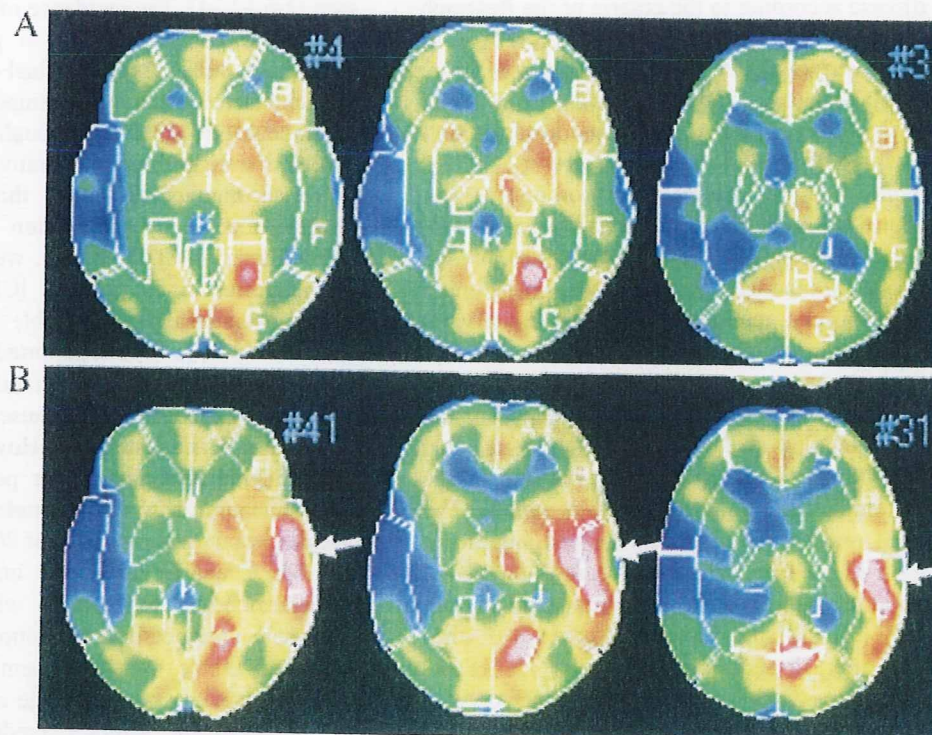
N*-isopropyl-*p*-[<sup>125</sup>I]iodoamphetamine single-photon emission computed tomographic scans before (A) and after left STA-MCA anastomosis (B). As compared to preoperative finding in (A), marked increase in CBF at the site of the anastomosis was evident postoperatively (arrows in B) in accordance with the manifestation of aphasia. Symptoms completely disappeared 12 days after surgery.
